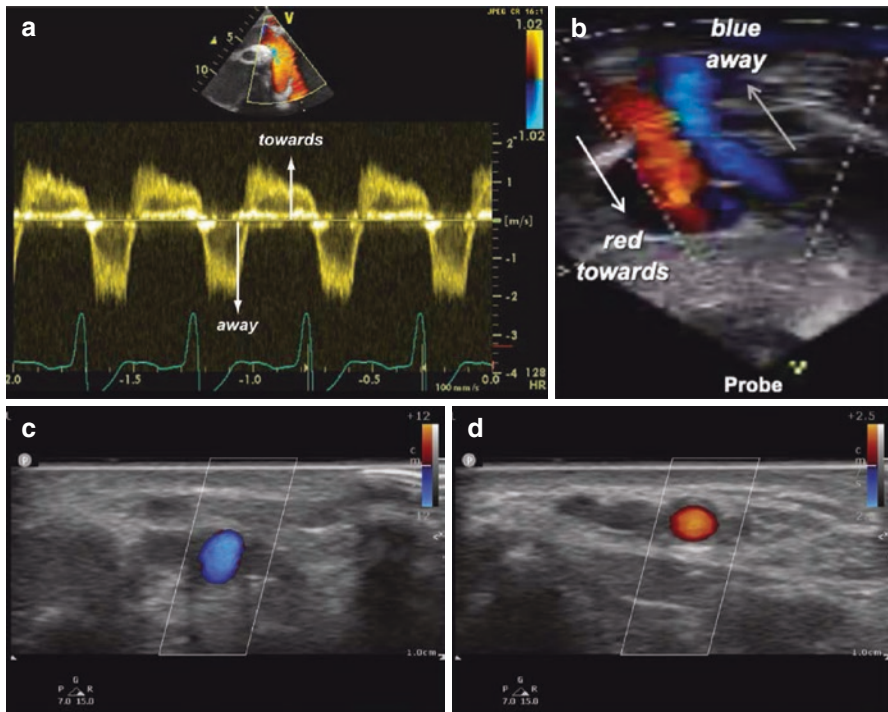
Spectral and color Doppler imaging. (a) Spectral Doppler obtained in the descending aorta with positive Doppler shift representing flow moving toward the transducer and negative Doppler shift representing flow moving away from the transducer. (b) Color Doppler with flow moving toward the transducer represented in red and flow
